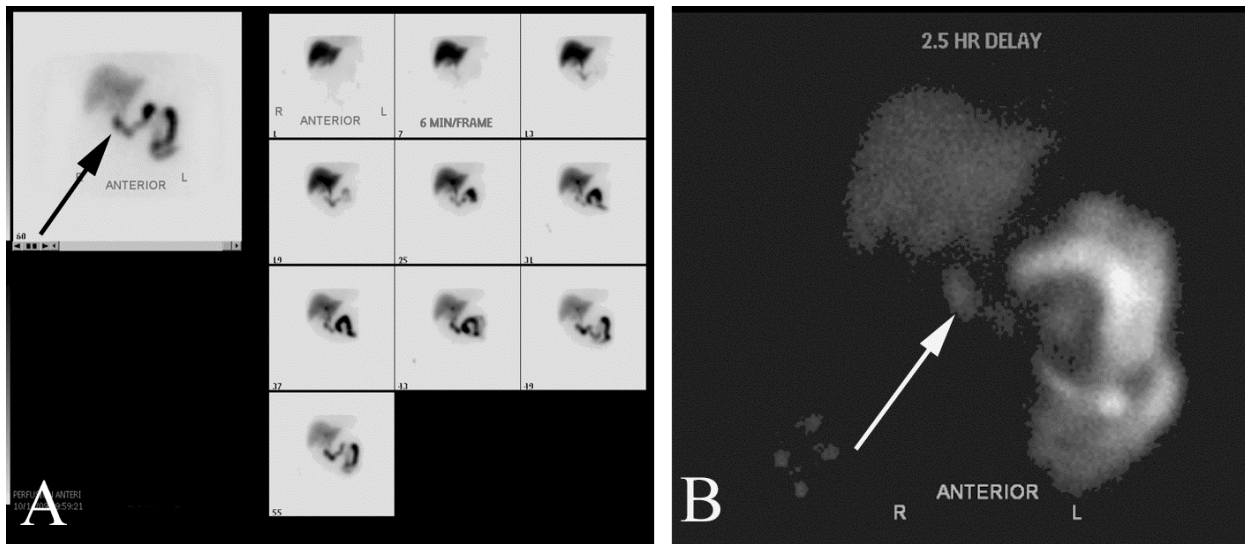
Cholecystitis on a nuclear medicine study in a 79 year old man with equivocal right upper quadrant pain and gallstones seen on an ultrasound study (not shown). A. HIDA scan through one hour shows no visualization of the gallbladder, although there is visualization of the liver, duodenum (arrow), and small bowel. B. Nuclear medicine scan done at 2.5 hours still shows only the duodenum (arrow) without gallbladder activity. The patient was taken to the operating room where acute cholecystitis was confirmed.
